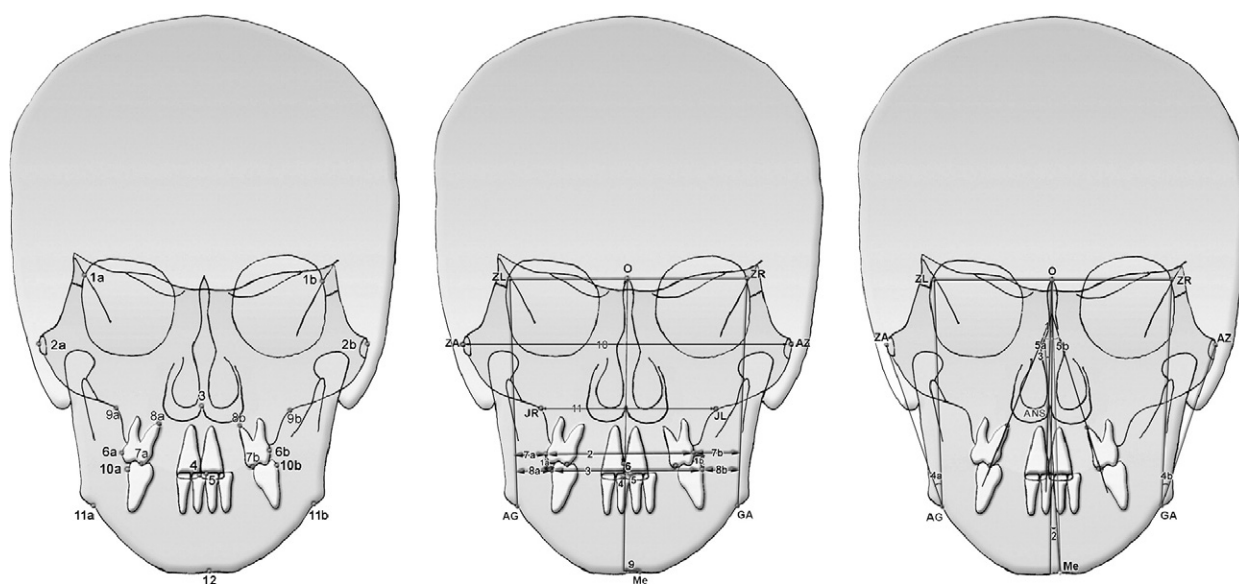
A, Landmarks used in posteroanterior cephalometric radiographs (a, right side; b, left side): 1, ZR and ZL, intersection point of zygomaticofrontal suture with orbita; 2, ZA and AZ, center of root of zygomatic arch; 3, ANS, upper point of anterior nasal spine; 4, U1, proximal incisal point between maxillary central incisors; 5, L1, proximal incisal point between mandibular central incisors; 6, U6, buccal contour crest of maxillary first molar; 7, U6P, palatal cusp tip of maxillary first molar; 8, U6A, palatal root apex of maxillary first molar; 9, JL and JR, intersection point of tuber maxilla and zygomatic arch on jugular process; 10, L6, buccal contour crest of first molars; 11, AG and GA, lateral and inferior point of antegonial protuberentia; 12, Me, menton. B, Linear measurements of posteroanterior cephalograms: 1, molar relationship (MR); 2, upper intermolar width (UIMW); 3, lower intermolar width (LIMW); 4, maxillary dental midline to midsagittal plane (U1-MSP); 5, mandibular dental midline to midsagittal plane (L1-MSP); 6, maxillary and mandibular dental midline distance (U1-L1); 7, maxillary molar-facial plane distance (U6-FP); 8, mandibular molar-facial plane distance (L6-FP); 9, menton-midsagittal plane distance (Me-MSP); 10, facial width (FW), distance between AZ and ZA points; 11, maxillary base width: distance between JR and JL points. C, Angular measurements of posteroanterior cephalograms: 1, transverse maxillary position angle (TMxA), angle between O-ANS line and midsagittal plane; 2, transverse mandibular position angle (TMdA), angle between O-Me line and midsagittal plane; 3, transverse jaw relationship (TJR), angle between O-ANS line and O-Me line; 4, positional symmetry angle (PSA), angle between ZA-AG-ZR points on right side and ZL-GA-ZL points on left side; 5, inclination angle of the maxillary first molar (U6 inc), angle between maxillary molar axis (line passing through palatal cusp tip and palatal root apex) and midsagittal plane.
